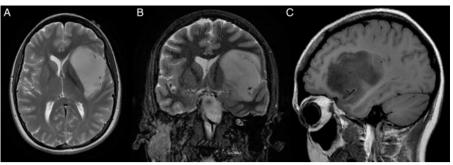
Axial (A) and sagittal (B) T2-weighted magnetic resonance imaging (MRI), as well as sagittal T1-weighted imaging (C) demonstrating a large $(7 \times 6 \times 4.4 \text{ cm})$, T2-hyperintense lesion (hypointense on T1) in the left insula with mild expansion of the Sylvian fissure.
